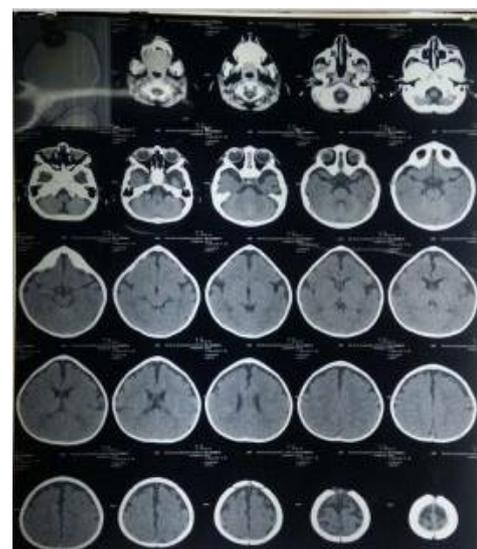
CT scan showing features of mild trigonocephaly.
